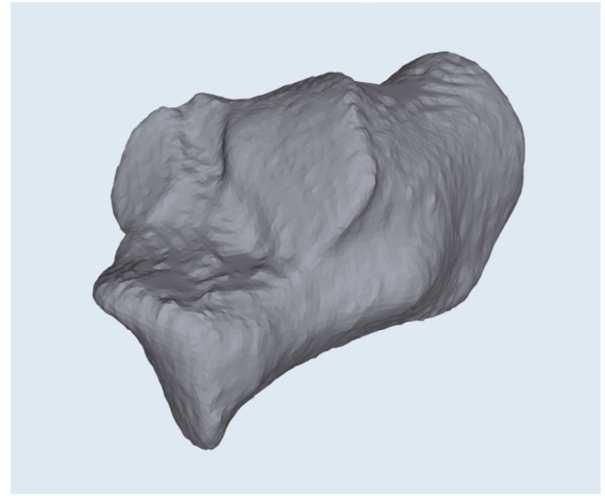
The upper surface of the calcaneus through 3D CT image reconstruction.
